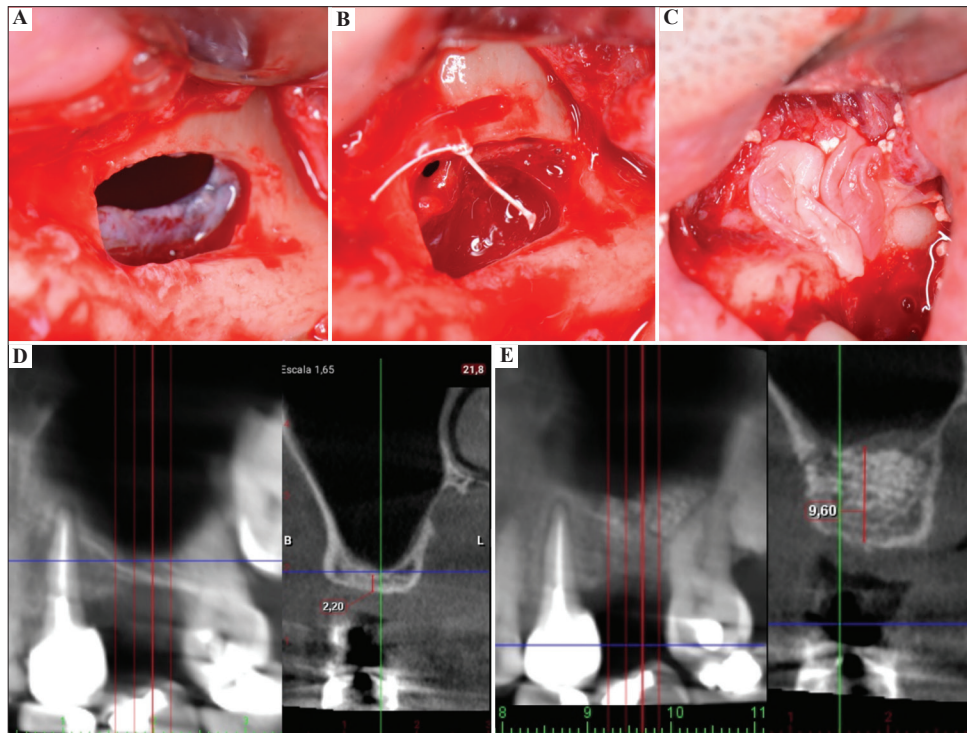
Patient no. 1. (A) Class I perforation of the Schneiderian membrane (SM). (B) The SM was sutured, and the perforation area was sealed with two overlapping leukocyte and platelet-rich fibrin (L-PRF) membranes. (C) Subsequently, the defect was filled with particulate bone graft in combination with two sliced L-PRF membranes and the antrostomy was closed with two additional L-PRF membranes. (D) Initial cone-beam computed tomography (CBCT). (E) CBCT at 6 months post-surgery.
